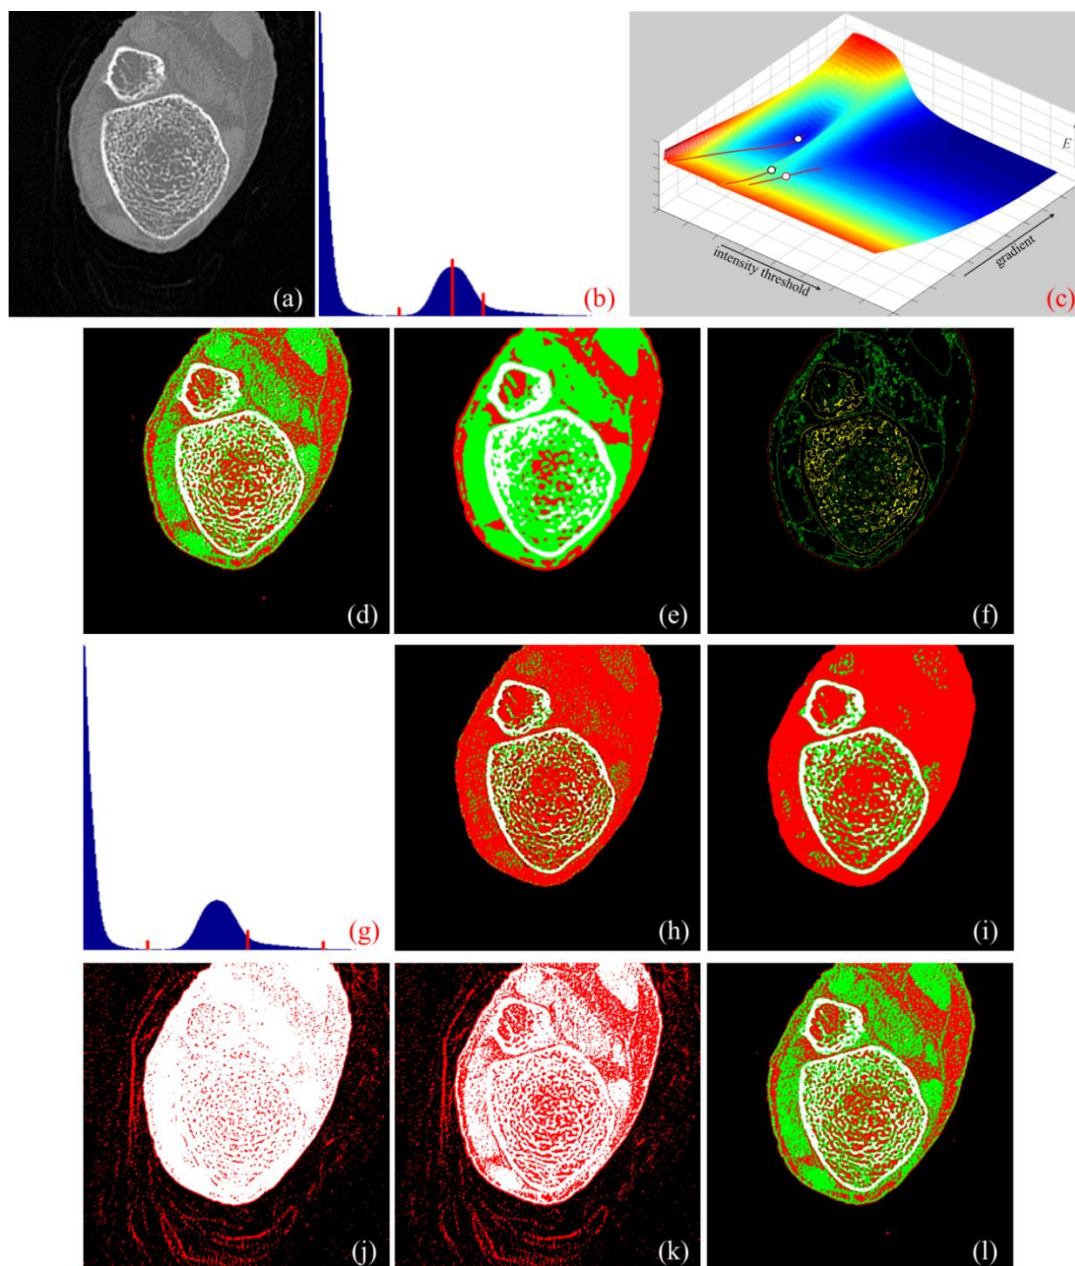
Results of application of different thresholding methods on a CT image slice of lower abdomen. (a) Original CT image slice. (b) Optimum thresholds (red lines). (c) The energy surface with valley lines (red) and optimum threshold and gradient parameters (hollow circles). (d) Thresholded regions in different colors as applied to the original image. (e) Same as (d), but applied to a smoothed image. (f) Object class uncertainty maps at different optimum thresholds. Note that the class uncertainty image highlights different tissue interfaces at different optimum thresholds. (g,h,i) Same as (b,d,e), respectively, but for Otsu's method. (j,k,l) Results of thresholding as obtained by the MSII, ME, MHUE algorithms, respectively.
